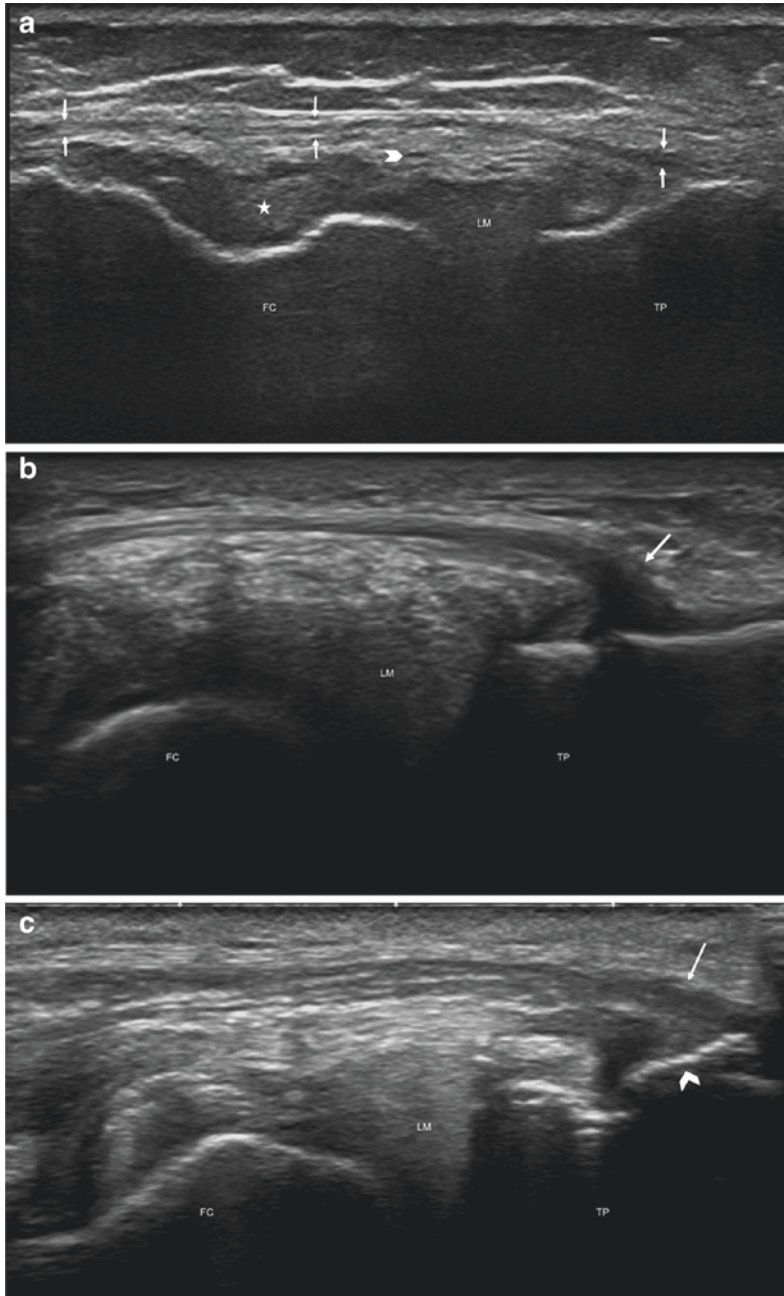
Appearance of anterolateral ligament (ALL) on ultrasonography. Major axis of the anterolateral ligament of the knee; coronal plane image showing the ligament in the major axis. a Ultrasonography of normal ALL (arrows): hypoechoogenic, fibrillar, thin structure crossing superficially the inferior genicular artery (arrow-head) and popliteal tendon (star). b Ultrasonography of injured ALL: the tibial insertion is hypoechoogenic and thickened (arrow) with fluid accumulation in the soft tissues around the ligament. c Ultrasonography of injured ALL: the tibial insertion is hypoechoogenic and thickened (arrow) and there is a bone avulsion at the tibial enthesis (arrow-head), i.e., Segond fracture. FC femoral condyle, LM lateral meniscus, TP tibial plateau. *Copyright: Fig. 2. Faruch Bilfeld M et al. Anterolateral ligament injuries in knees with an anterior cruciate ligament tear: Contribution of ultrasonography and MRI. Eur Radiol 2018;28:58–65*
